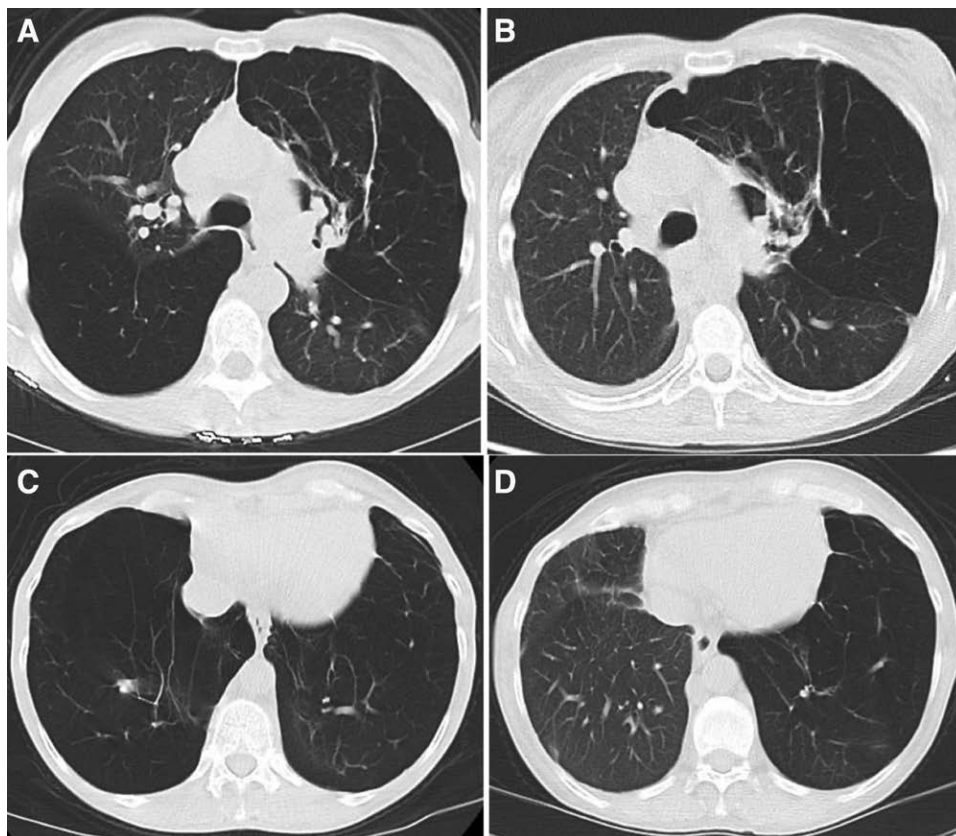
A and C, Representative sections from the pretransplant chest CT scan demonstrating extensive panlobular emphysema and coalescent cystic lung disease throughout both lungs with left upper lobe postoperative changes because of bleb resection. B and D, Sections from the posttransplant chest CT scan demonstrating normal right lung allograft parenchyma. CT, computed tomography.
